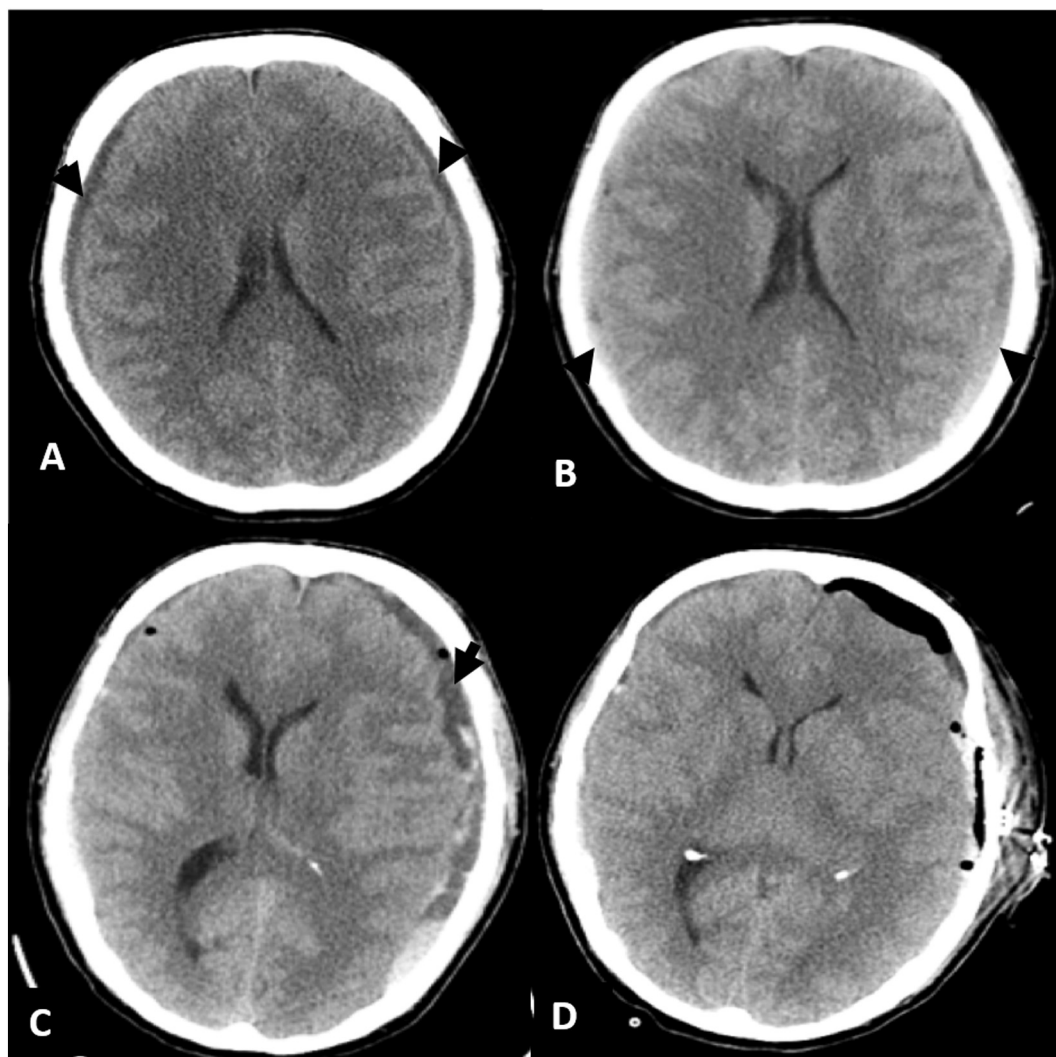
Axial CT of the head on presentation (A), 7 days after presentation (B), 4 days after bilateral burr hole drainage (C), and post-craniotomy (D) demonstrating the subdural hematomas.
